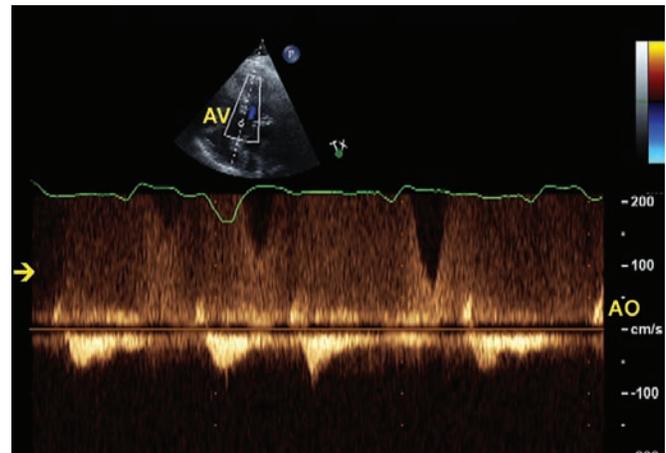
Apical five chamber view. The arrow points to flow signals moving continuously towards the LV apex where the cannula is placed.
